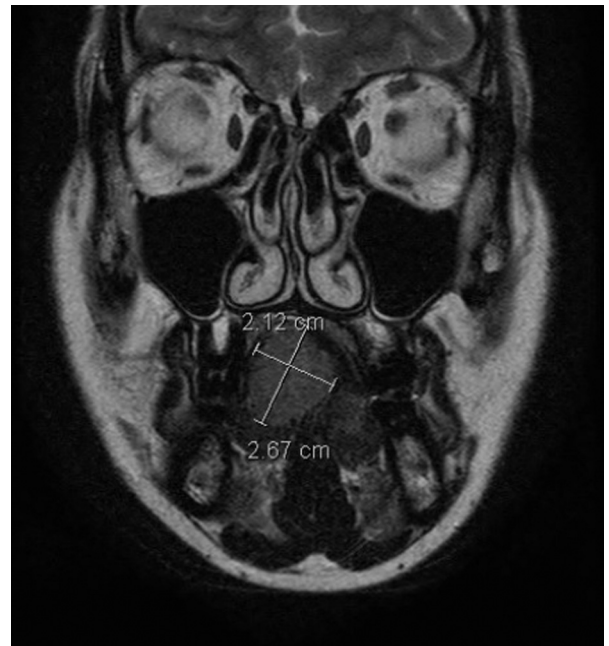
MRI orbit, face and neck with gadolinium: coronal T2 weighted cut showing the tongue mass with a maximum diameter of 2.67 cm.
